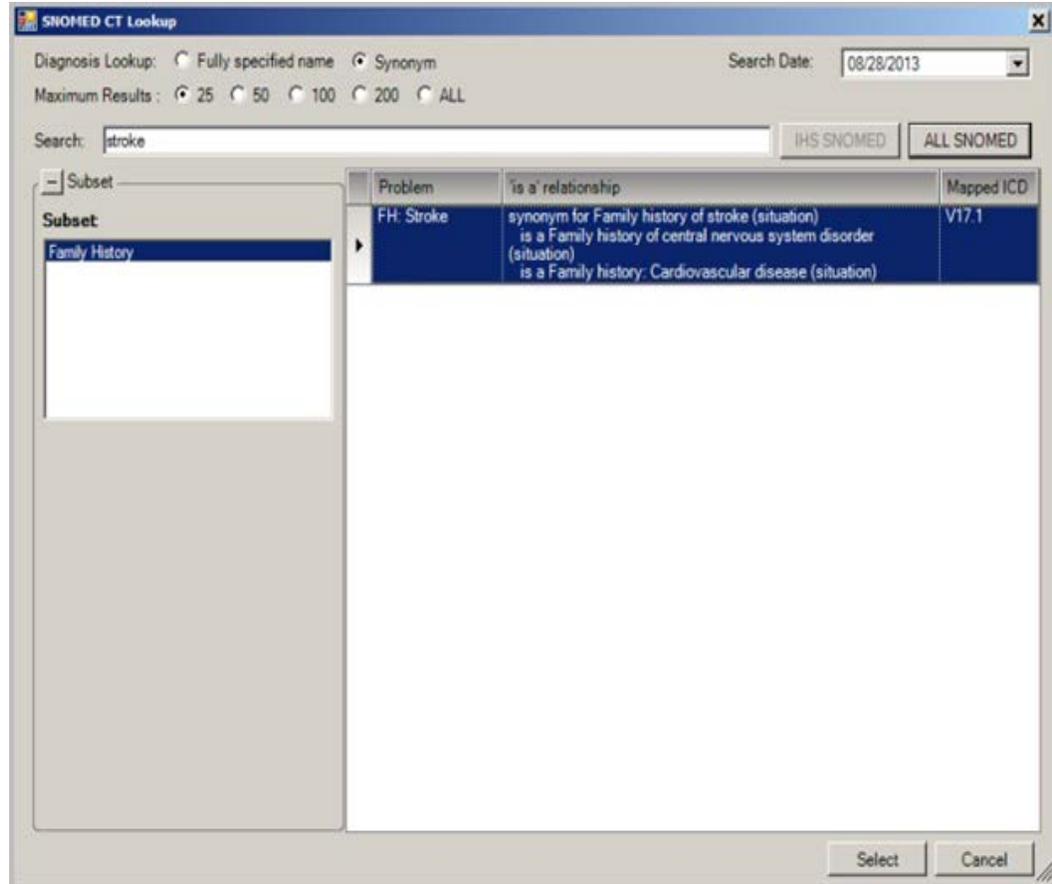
SNOMED CT Lookup
